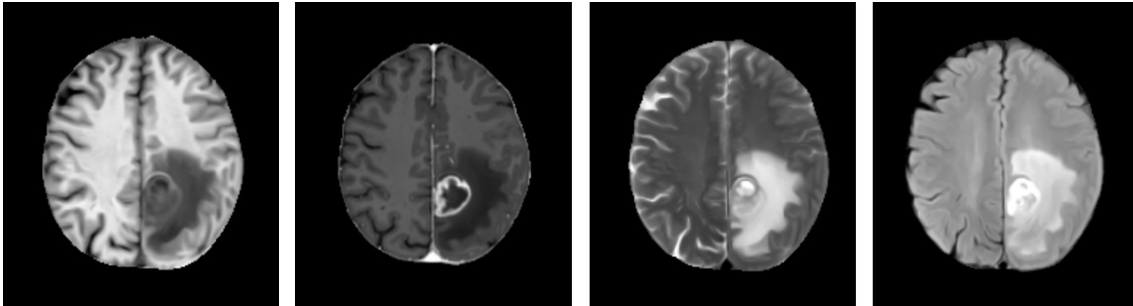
Example of anatomical presurgical magnetic resonance images typically acquired in an astrocytoma grade 4 study. From left to right: T1-weighted, T1CE-weighted, T2-weighted, and FLAIR MRI. Images were collected during the *MTS4UP* multicenter study.
